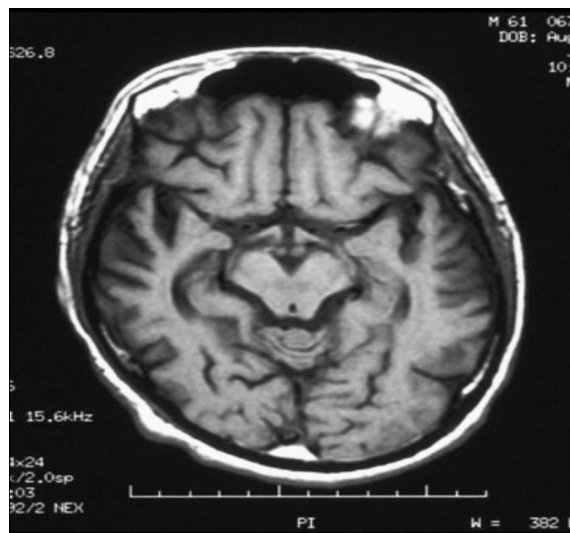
Axial, T1-weighted magnetic resonance imaging (MRI) scan shows a dilated sylvian fissure caused by adjacent cortical atrophy.
